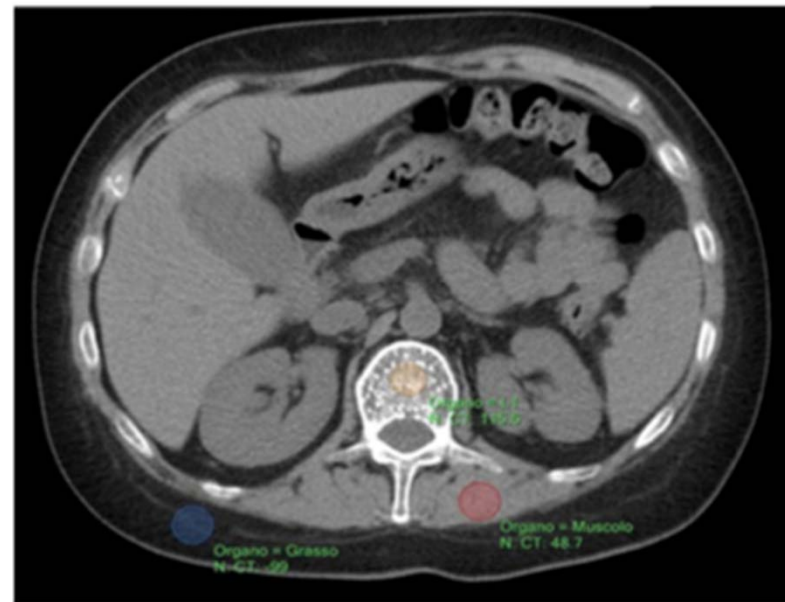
Axial CT scan in a patient with Thalassemia major. ROIs for vertebral body (orange circle), paraspinal muscle (red circle) and subcutaneous fat (blue circle) are shown with their respective CT numbers (in Hounsfield Units, HU)
